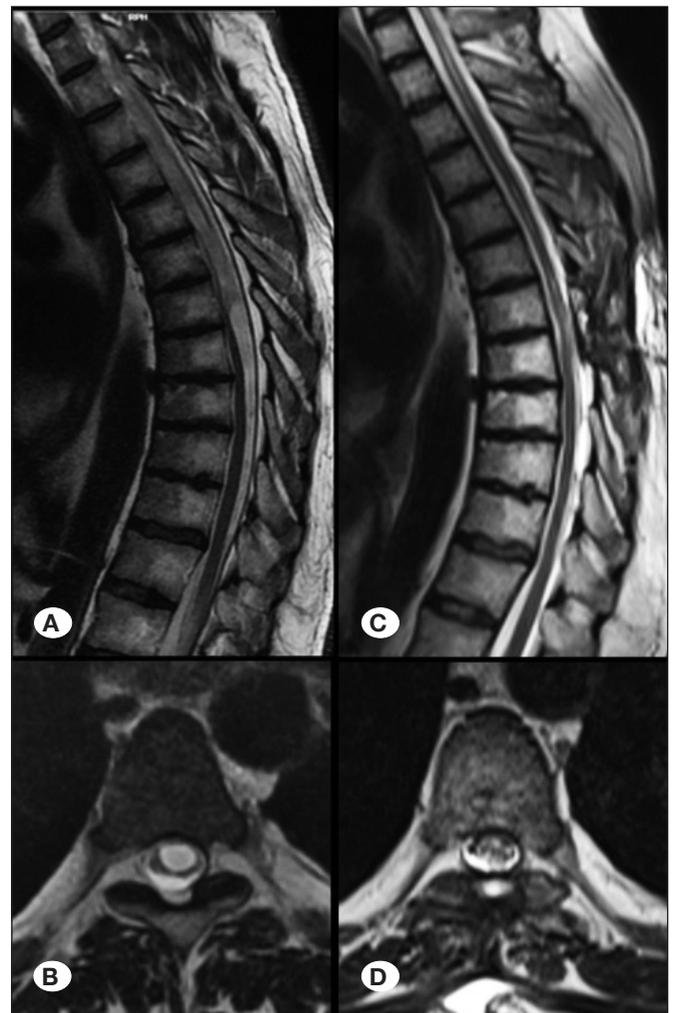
Case Sample 1: Preoperative sagittal (A) and axial (B) T2 MRI images of an arachnoid cyst on thoracic level. 1st-year postoperative sagittal (C) and axial (D) T2 MRI images revealed complete excision of the cyst. It was observed that the syrinx decreased postoperatively.
